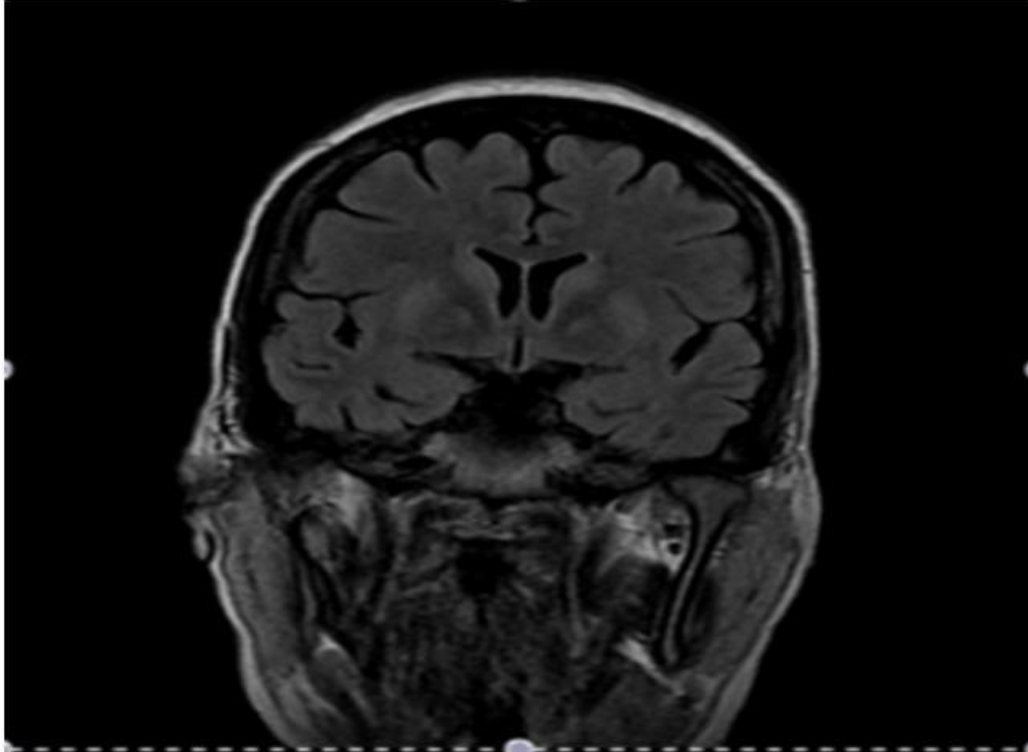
MRI of brain showing abnormal signal in putamina, caudate heads and globipallidi, consistent with hypoxic ischemic injury.
